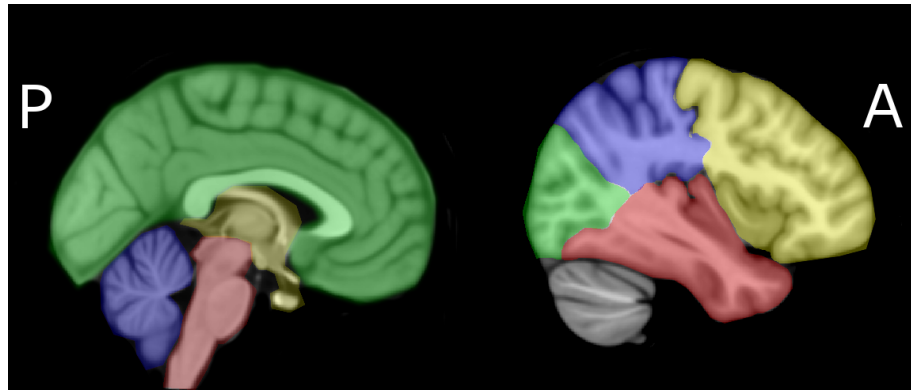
MRI derived visualization of the human brain and cerebrum segmentations with color highlighting. Left: brain stem is colored red, cerebellum is colored blue, diencephalon is colored yellow and cerebrum green. Right: frontal lobe is colored yellow, parietal lobe blue, temporal lobe red and occipital lobe is colored green, the cerebellum is also visible and uncolored. In the images, anterior side is on the right and posterior on the left.
